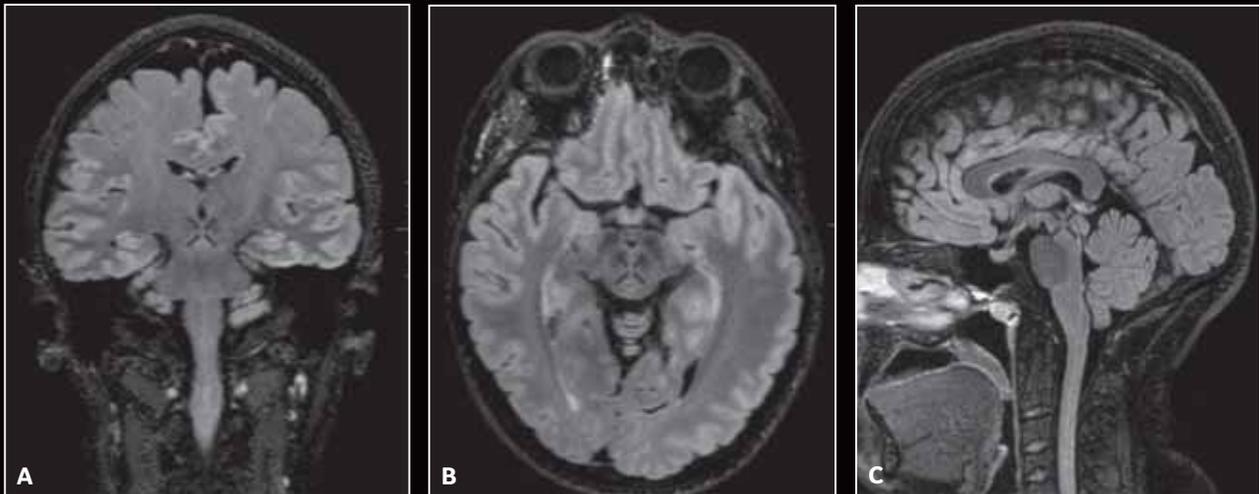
Cube T2 FLAIR with HyperSense. With one volume/plane acquisition, the user can reformat in multiple planes. Thin slices with no gap can increase diagnostic confidence. Sequence acquired in 4:16 min. (A) and (B) are reformatted from (C).
